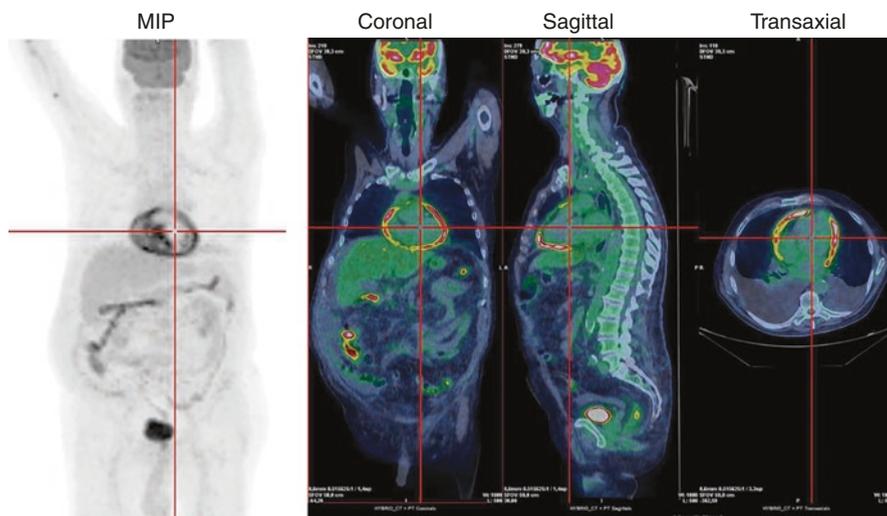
PET/CT imaging in pericarditis. 1-month after a febrile prodromal syndrome followed by persistent asthenia and worsening dyspnoea, a 67 year old patient was admitted with atrial fibrillation. Serologic findings and echocardiographic/CMR images were suggestive of incessant pericarditis. PET/CT scan confirmed the diagnosis revealing diffuse uptake of ^{18}F FDG in the pericardial layers without myocardial involvement and associated large bilateral pleural effusions
